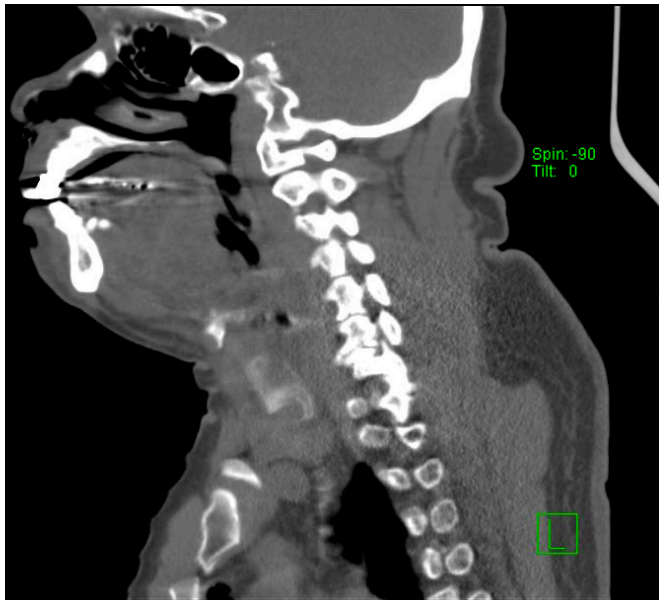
CT of the head and neck in the sagittal view.
